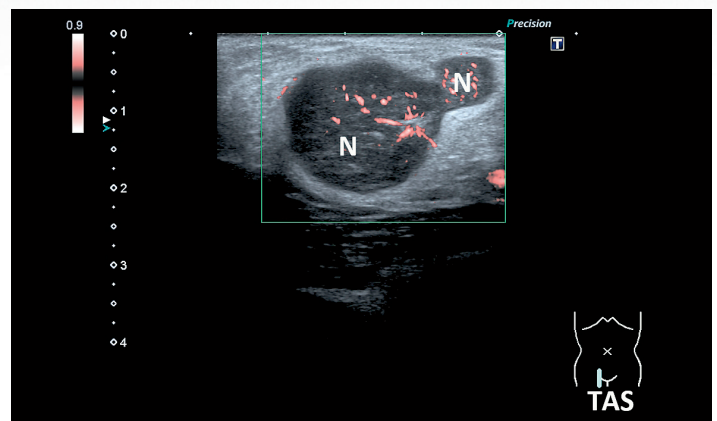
Transabdominal ultrasound utilising SMI confirmed reactive inguinal nodes (N) in the case of Rt. lower pelvic pain.
